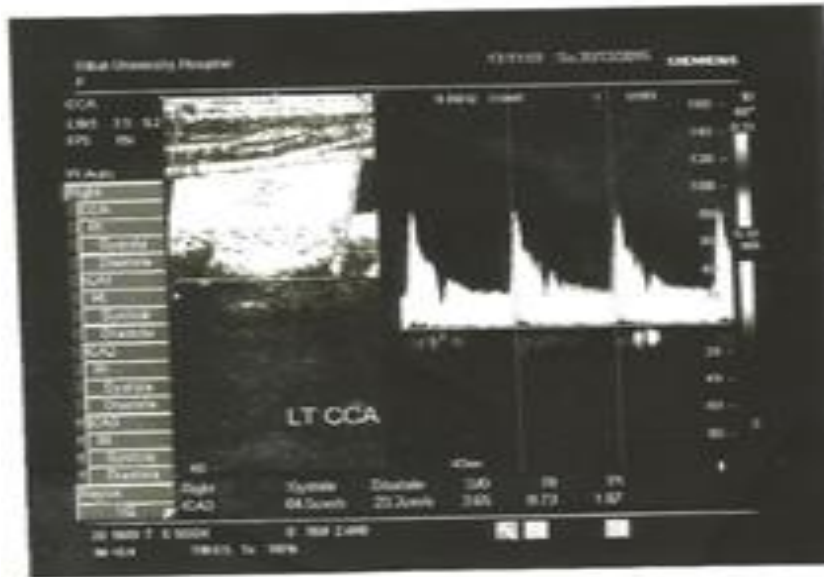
Lt CCA-female- 47 years diabetic patient with normal Doppler parameters.
